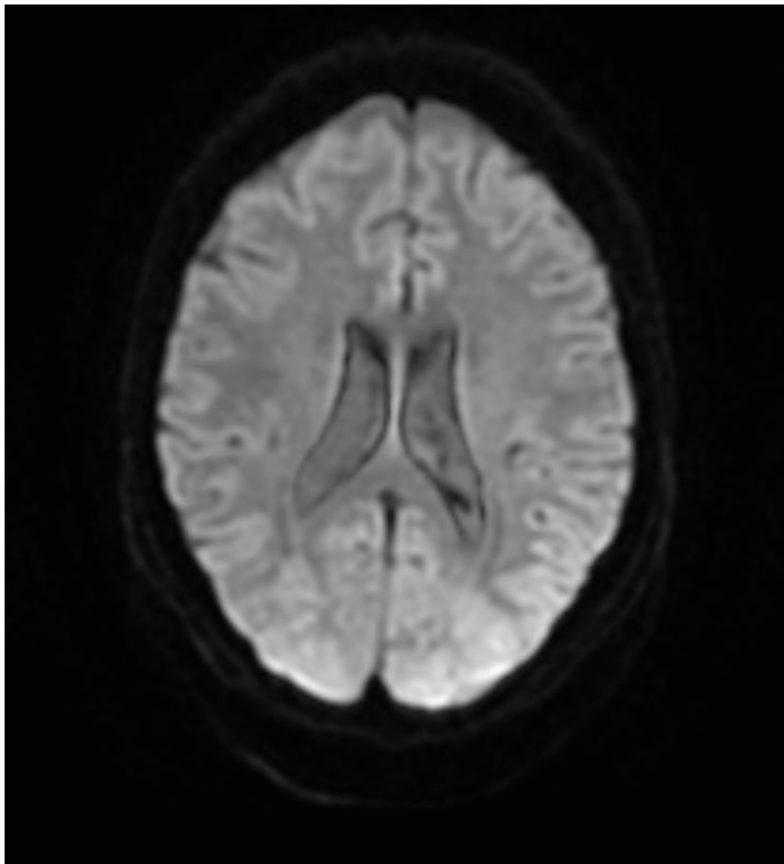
MRI DWI showing diffusion restriction in bilateral parieto-occipital region.
